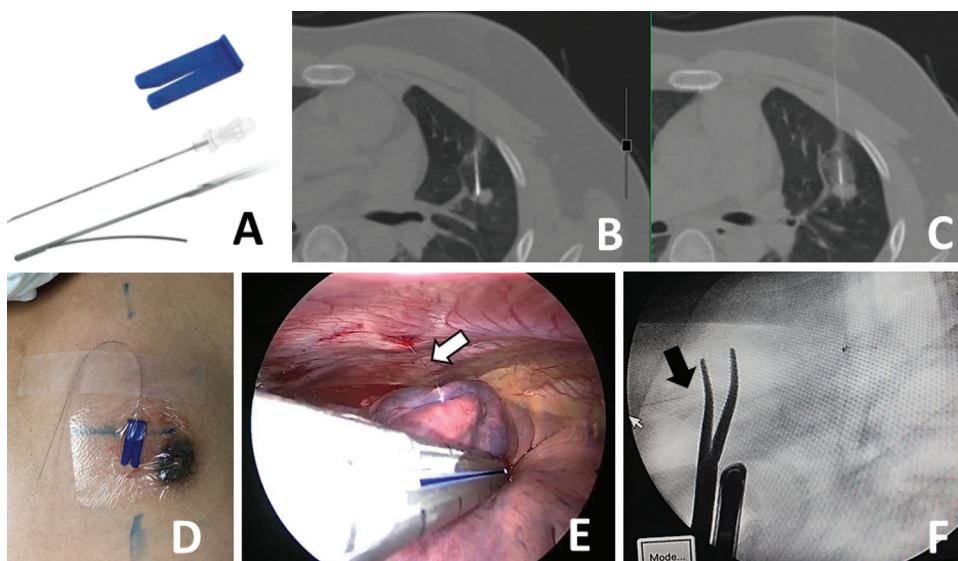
(A) Hook-wire needle localization using a standard non-repositionable breast localization needle in the present study institution, (B) Computed tomography (CT)-guided needle placement at the anterior border of a 1.1-cm solid nodule at the superior lingular segment of the left upper lobe, (C) Post-procedural CT image after hook-wire placement via the needle showing minimal parenchymal hemorrhage after needle removal, (D) A skin-retention clip is used to secure the position of a hook-wire during transfer to the operating room, (E) Intraoperative findings of hook-wire (white arrow) during the video-assisted thoracic surgery (VATS) procedure, (F) Fluoroscopy is used simultaneously with VATS to identify the tip of the hook-wire (black arrow) during wedge lung resection.
